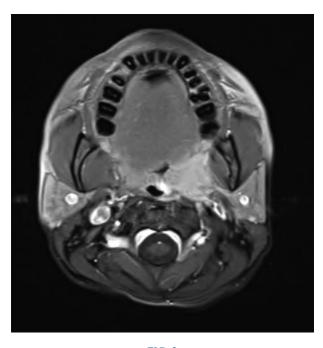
Axial, T1-weighted magnetic resonance imaging scan with gadolinium, showing a lesion in the left tonsillar fossa.
